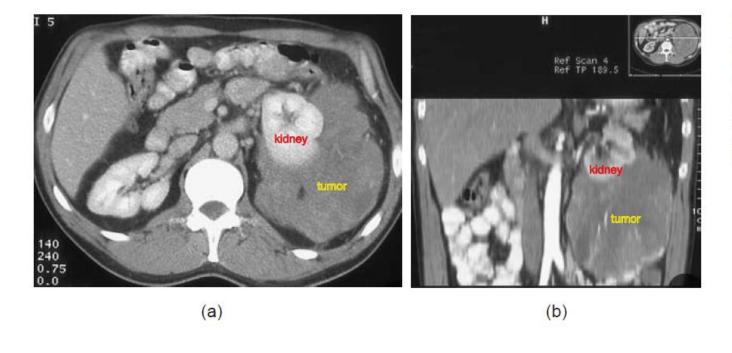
(a) Axial CT slice through the kidney showing a perirenal liposarcoma in the nephrographic phase after intravenous injection of contrast medium. (b) Reformatted coronal CT slice at the level of the aorta of the same patient. (Courtesy of Professor R. Oyen, Department of Radiology.)
